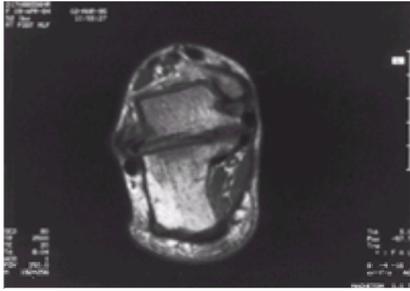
Subtalar fusion or coalition—a CT scan of the hindfoot of a 12-year-old child demonstrating the lack of definition of the cortex of the subtalar joint on the medial side of the heel.
